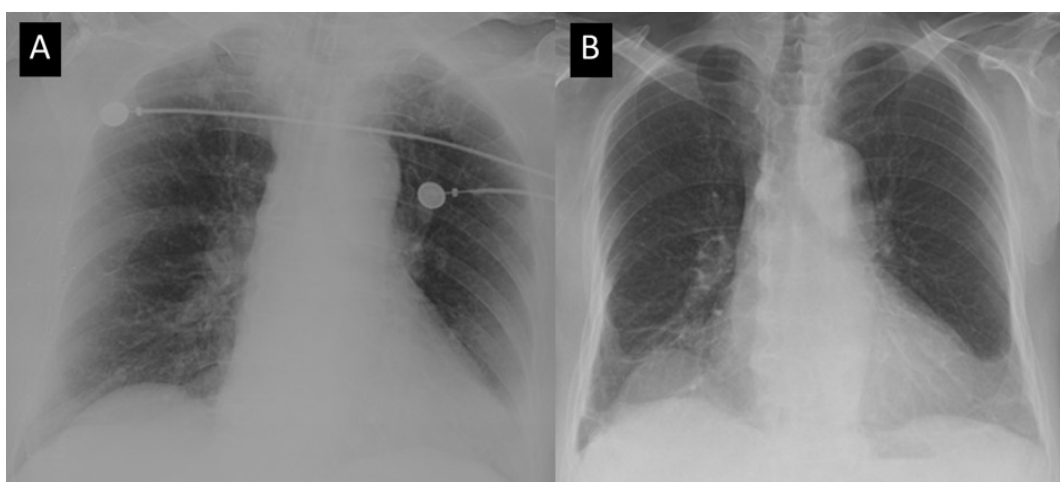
Chest roentgenography showing nonspecific reticular opacities and pulmonary congestion due to bradycardia and hypotension (A) and recovered after the treatment (B).
